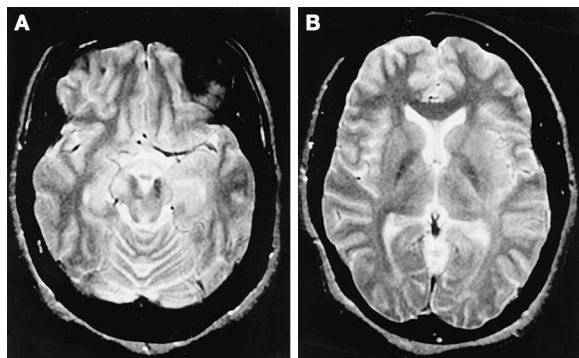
Axial T2-weighted magnetic resonance imaging scans, obtained at the initial presentation of the patient, demonstrating hyperintense signal in the brainstem and diencephalon (A). There is no evidence of a right posterior temporal vascular lesion (B).
